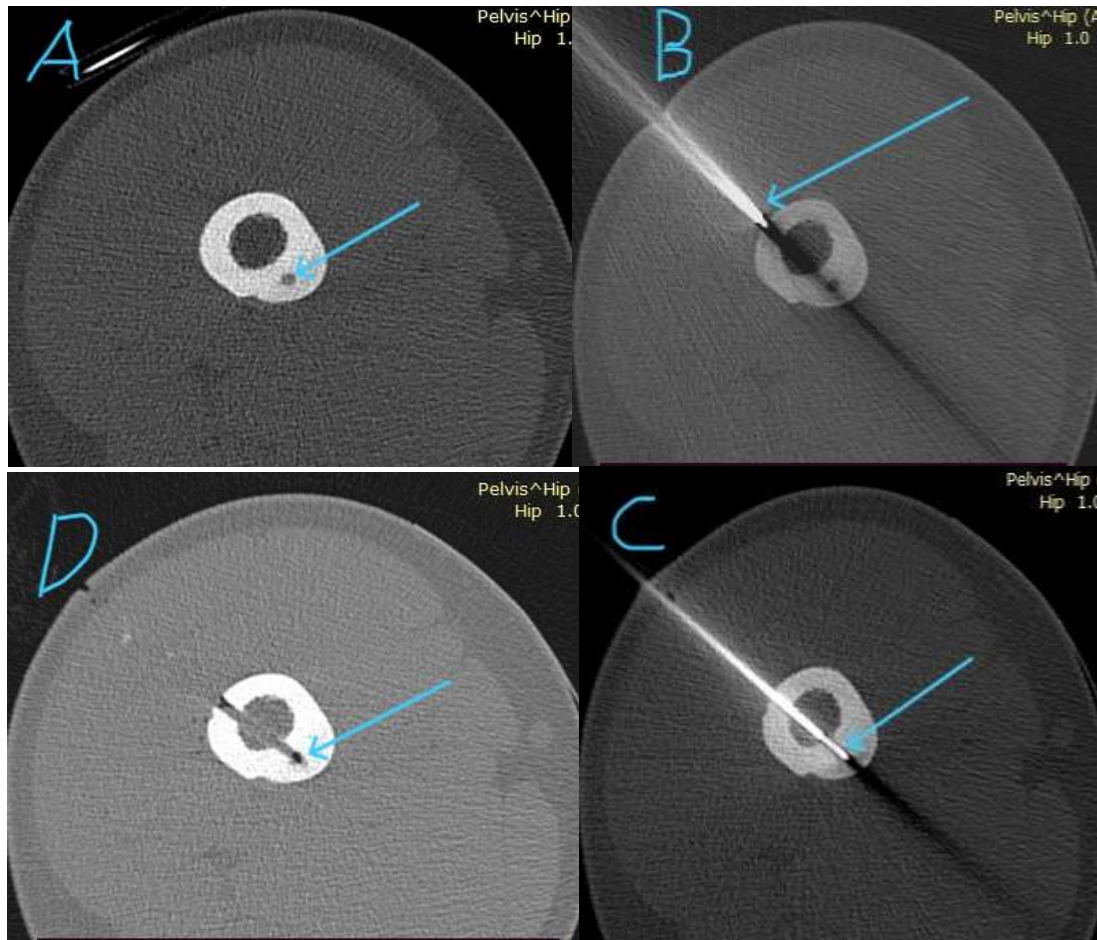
A) Pre-procedure axial CT image shows the hypodense nidus at the medial cortex of the right femoral shaft with bone sclerosis and significant cortical thickening. B) During the procedure, axial CT image shows the bone needle entrance from the lateral cortex. C) During the procedure, the axial CT image shows the tip of the RF electrode in the nidus. D) Immediately post-procedure axial CT image shows complete ablation of the nidus, no ablation site complications.
